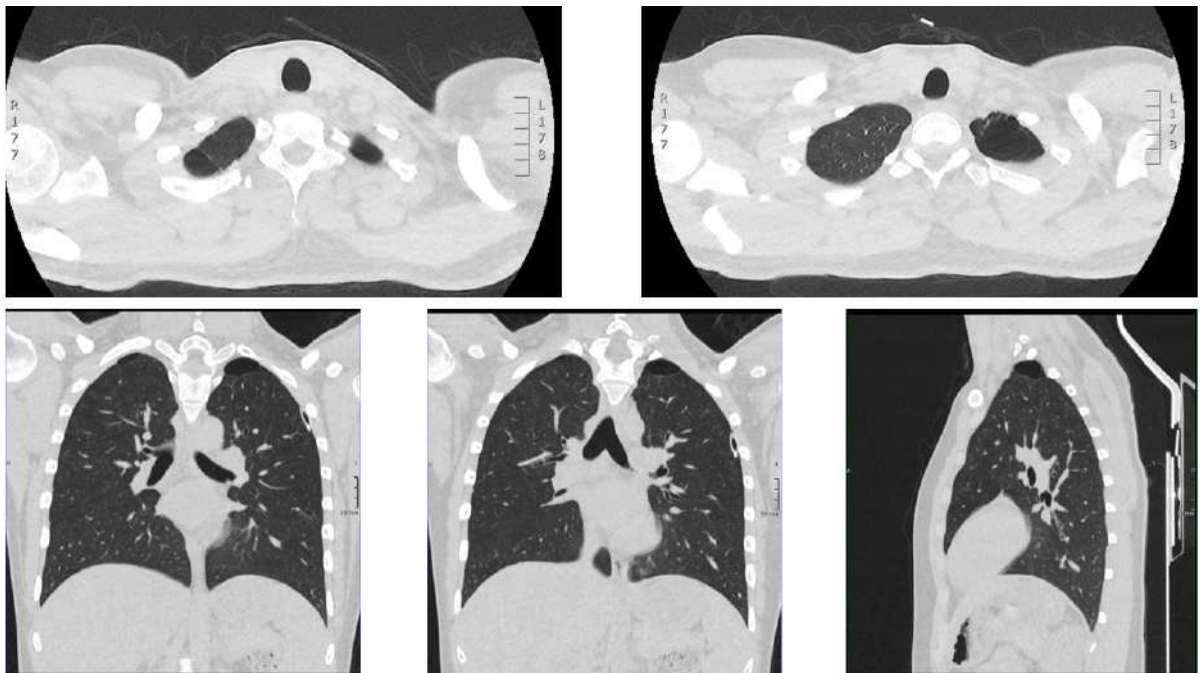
HRCT of a patient with bilateral apical bullae in axial (up), coronal and sagittal (down) window.
